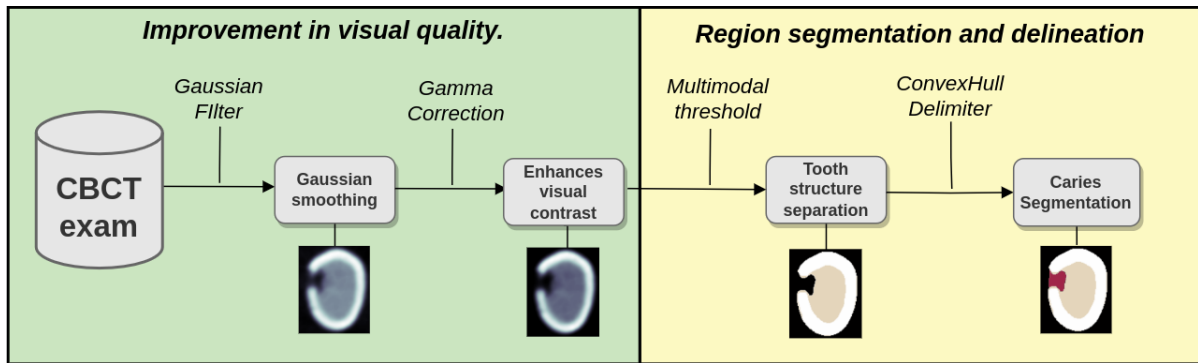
Preprocessing techniques and segmentation techniques to enhance CBCT images.
